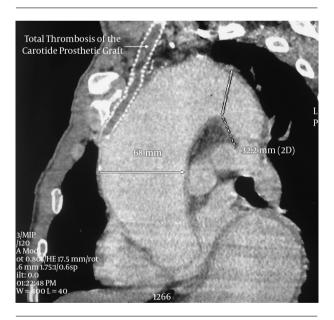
Computed Tomography Angiography Demonstrates an Ascending, Transverse, and Descending Thoracic Aortic Aneurysm
